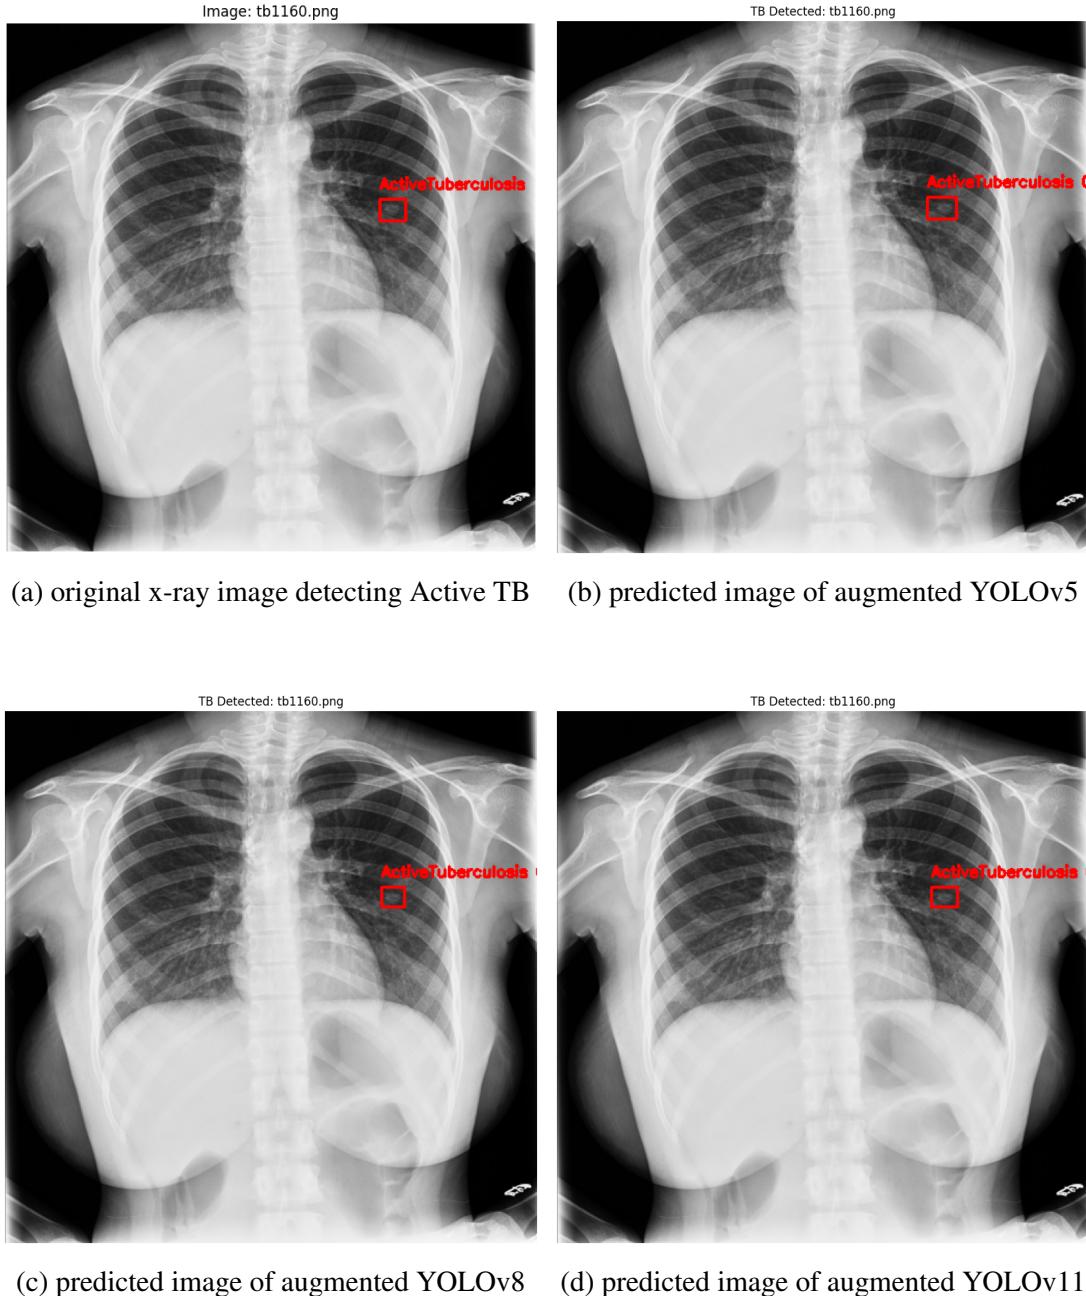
Comparison of original x-ray image of active TB with augmented yolo models(YOLOv5,YOLOv8,YOLOv11)
